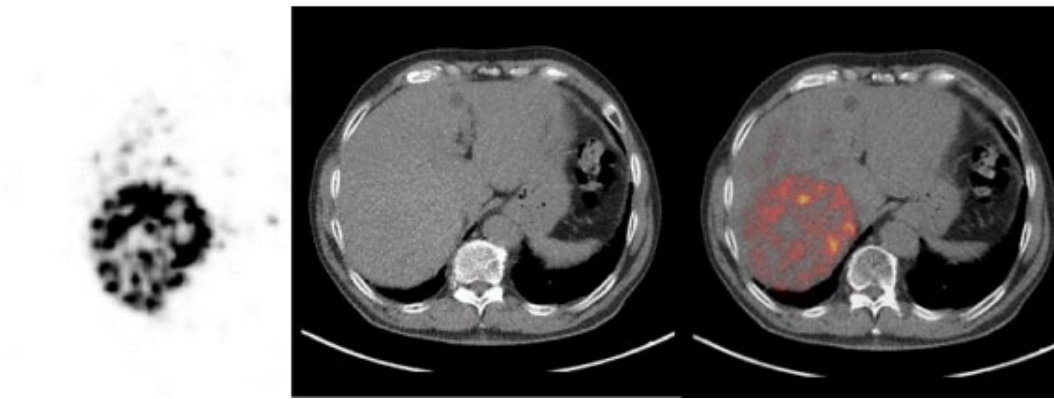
Representative images of ⁹⁰Y PET/CT
